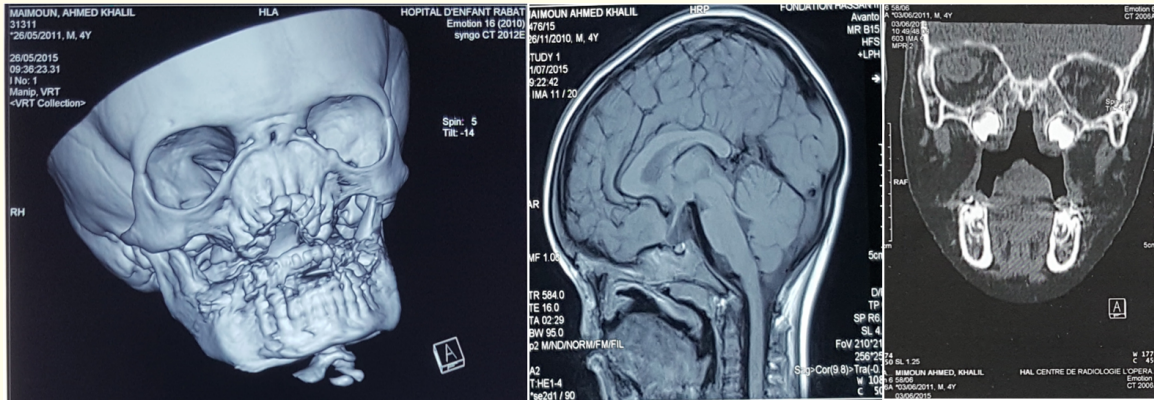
Preoperative 3D CT scan shows a facial malformation with absence of the pyramid and nasal cavities, palatine bone and ethmoid bone with significant hypoplasia of the maxilla. Ascension of the upper incisors which are visible inter-orbital.
